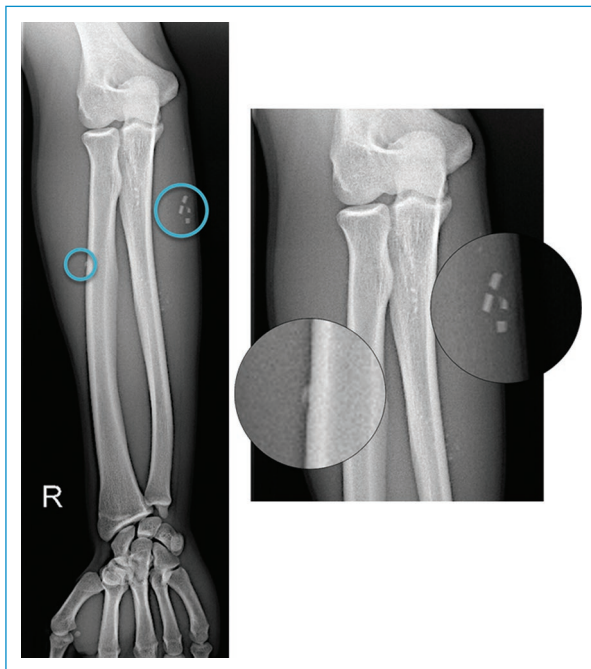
Radiography of the right forearm (anteroposterior view): the circles highlight five glass fragments located on the proximal third of the forearm (four on the medial and one on the lateral face).
